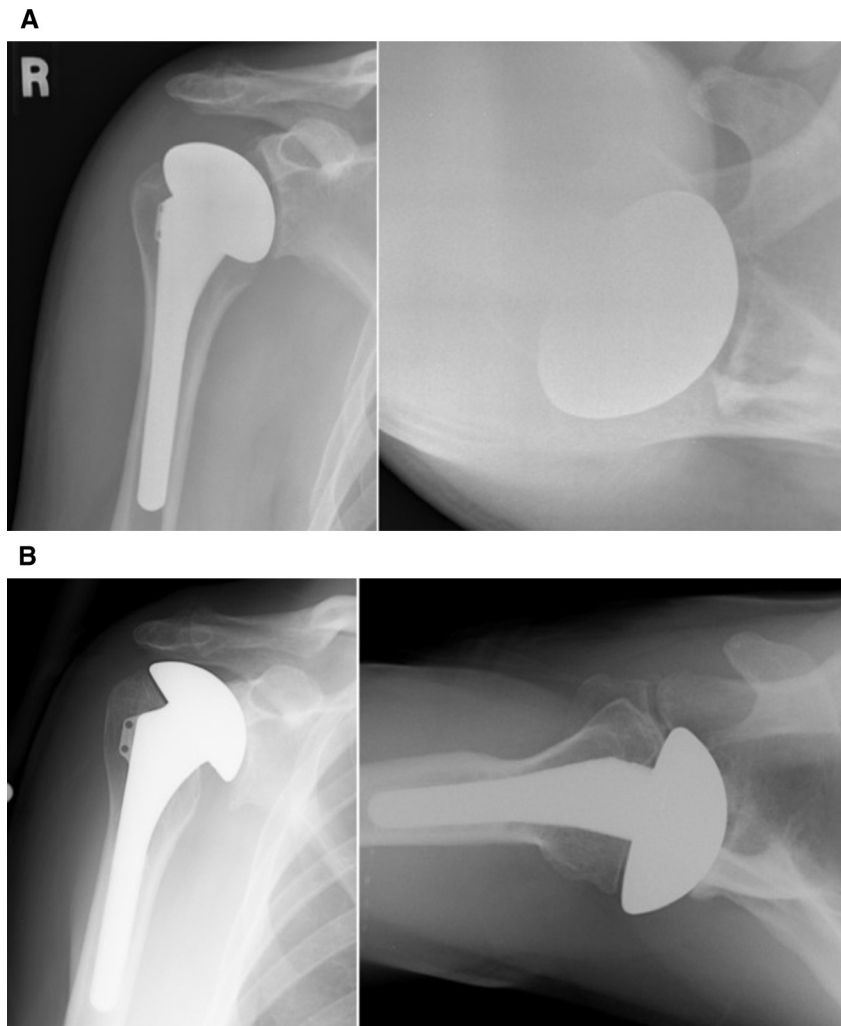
(A) Preoperative and (B) postoperative anteroposterior (*left*) and axillary (*right*) radiographs demonstrate a reduction in glenohumeral joint space 3 years after biologic resurfacing of the glenoid using a lateral meniscal allograft coupled with a hemiarthroplasty.
